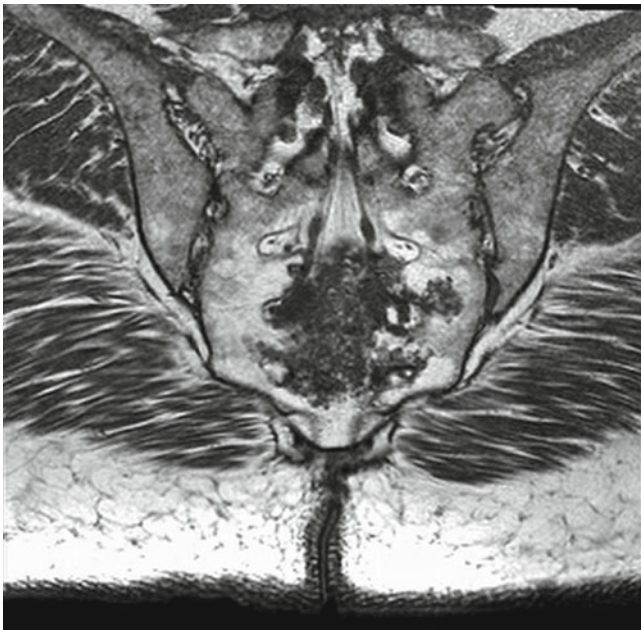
Coronal MRI image of sacral chordoma showing extensive calcifications, sometimes seen in chordoma
